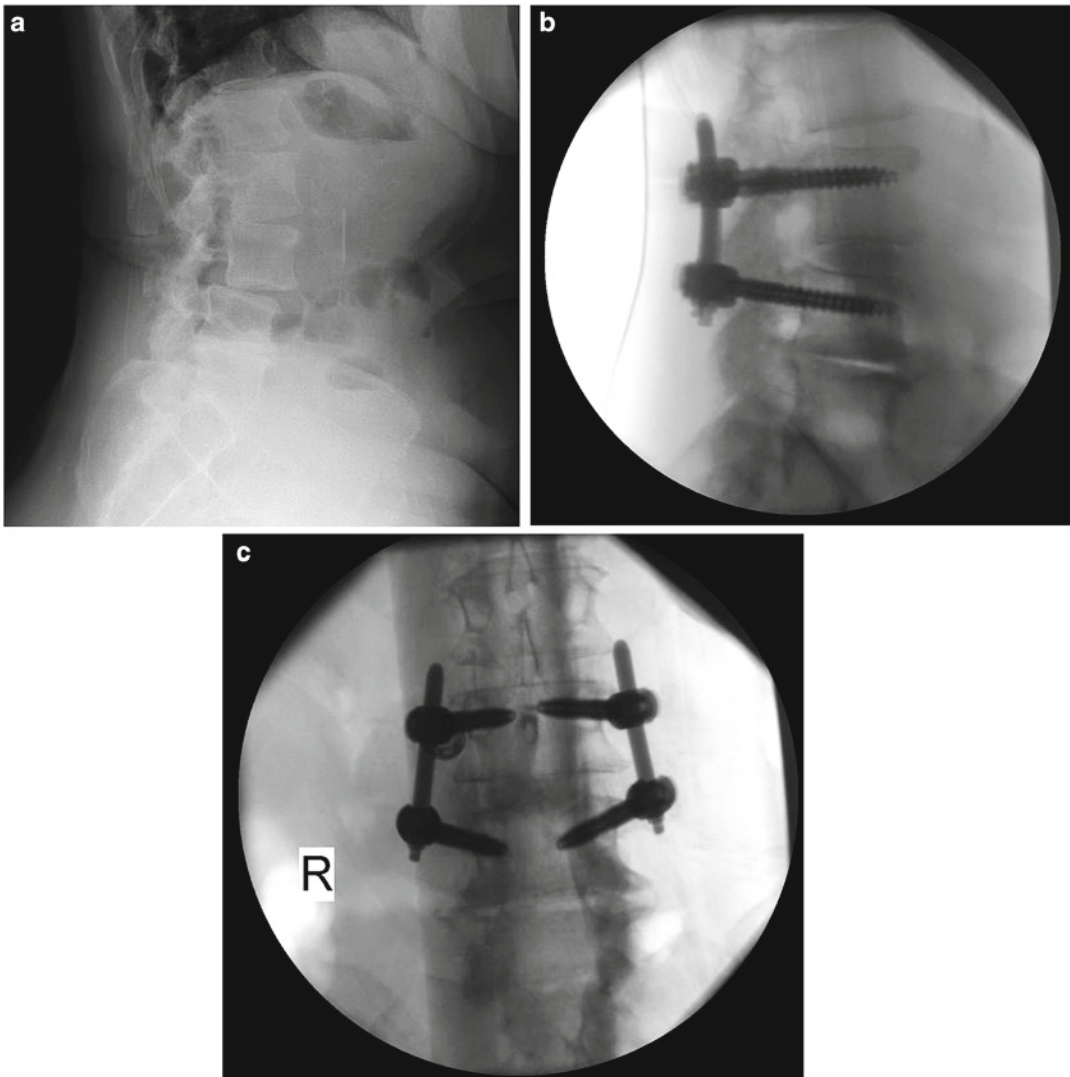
(a) Preoperative lateral standing X-ray of a patient with L3–L4 grade I spondylolisthesis. (b) Postoperative lateral image status post L3–L4 MIS TLIF. The listhesis is almost completely reduced. (c) Postoperative AP image
